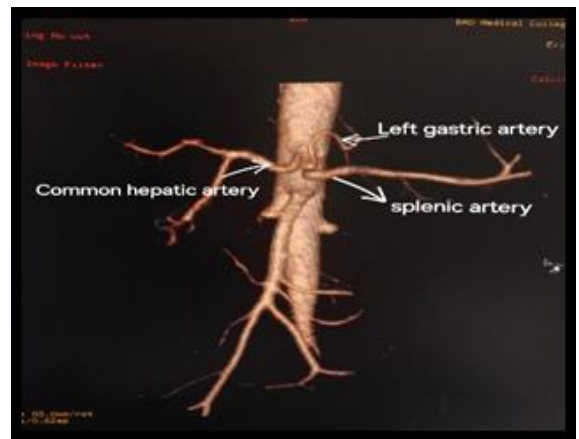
Computed tomography arterial phase images showing absent Celiac trunk (Uflacker's type VIII) with Left gastric artery, common hepatic artery and splenic artery each arising from aorta independently
